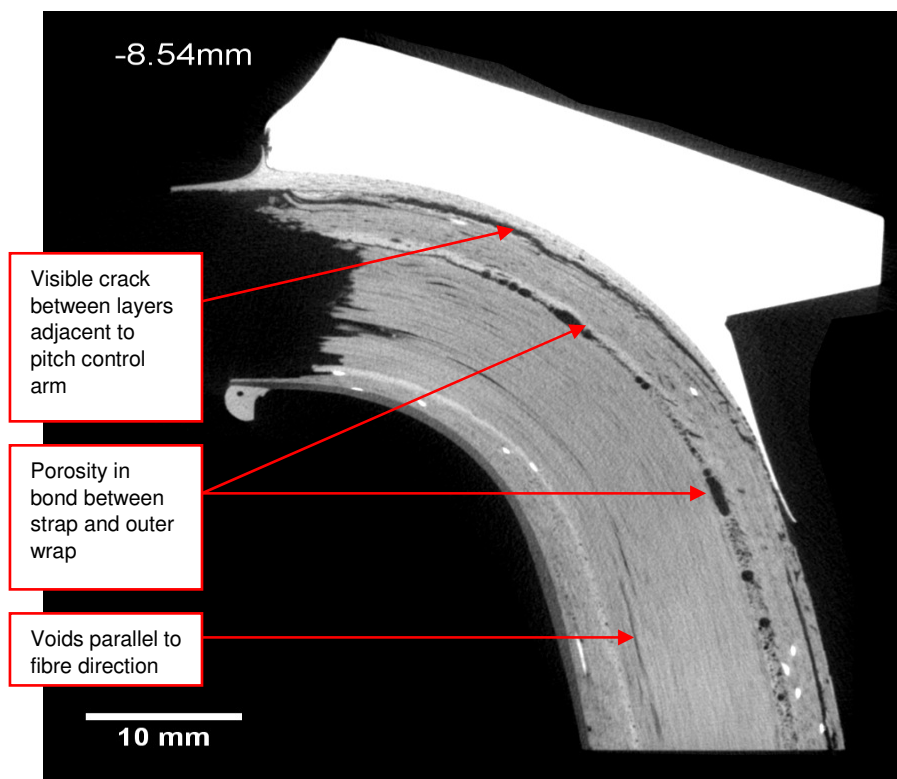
Section through White blade strap using X-ray tomography
